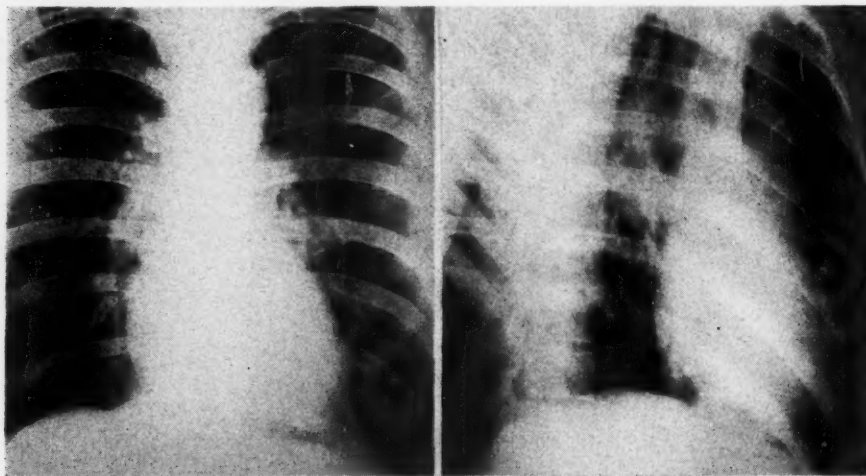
These roentgenograms appear to be normal, 18 months after operation.
